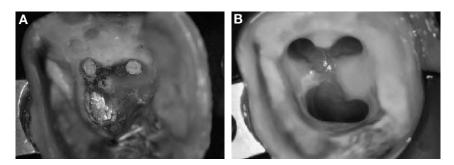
(A) Mandibular molar requiring retreatment shows presence of gutta-percha in two mesial and one distal canal. The remaining chamber contained remnants of sealer cement and necrotic tissue. (B) Removal of gutta-percha filling and use of ultrasonic instruments exhibits debridement of the chamber and the presence of an untreated fourth distal canal.
